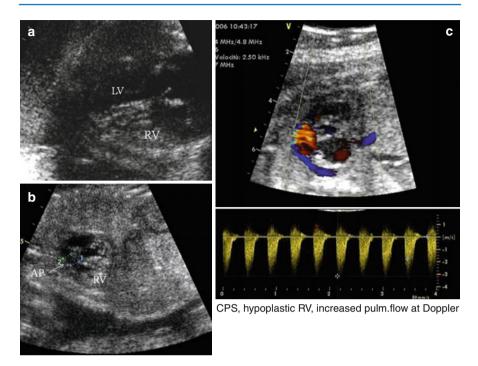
Case with critical pulmonary stenosis with hypoplastic RV (\mathbf{a}) , small pulmonary valve annulus (\mathbf{b}) , and increased pulmonary flow at Doppler (\mathbf{c})
